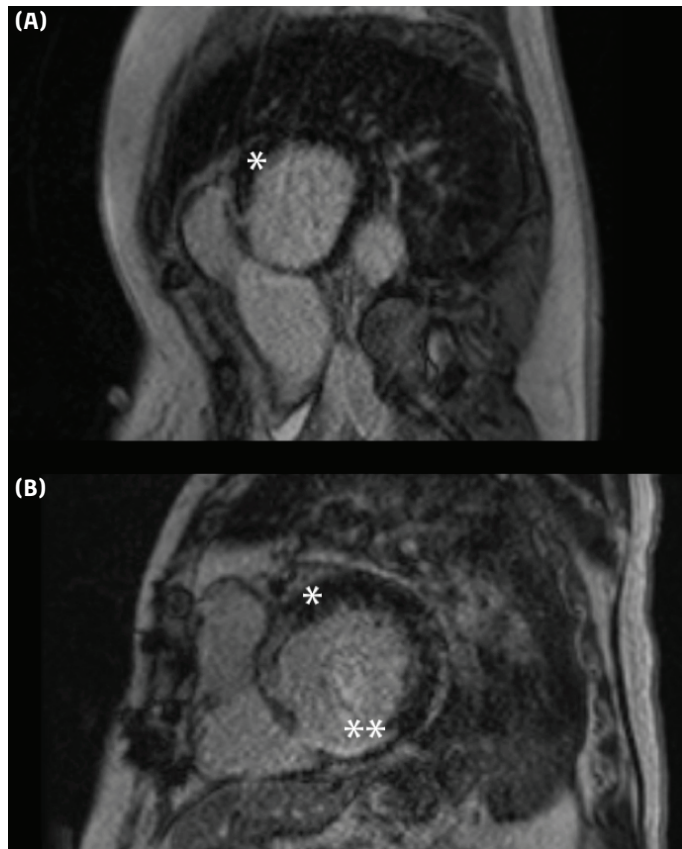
Cardiac magnetic resonance imaging of patients following ethanol ablation. (A) In the first case, minimal gadolinium enhancement was observed in the basal anterior septum, marked by an asterisk (*). (B) In the second case, two discrete areas of late gadolinium enhancement were identified. The first area, marked by a single asterisk (*), showed gadolinium enhancement in the basal anteroseptum. The second area, marked by a double asterisk (*), demonstrated transmural gadolinium enhancement in the inferior wall, attributed to a previous myocardial infarction and subsequent scar homogenization with radiofrequency ablation.
